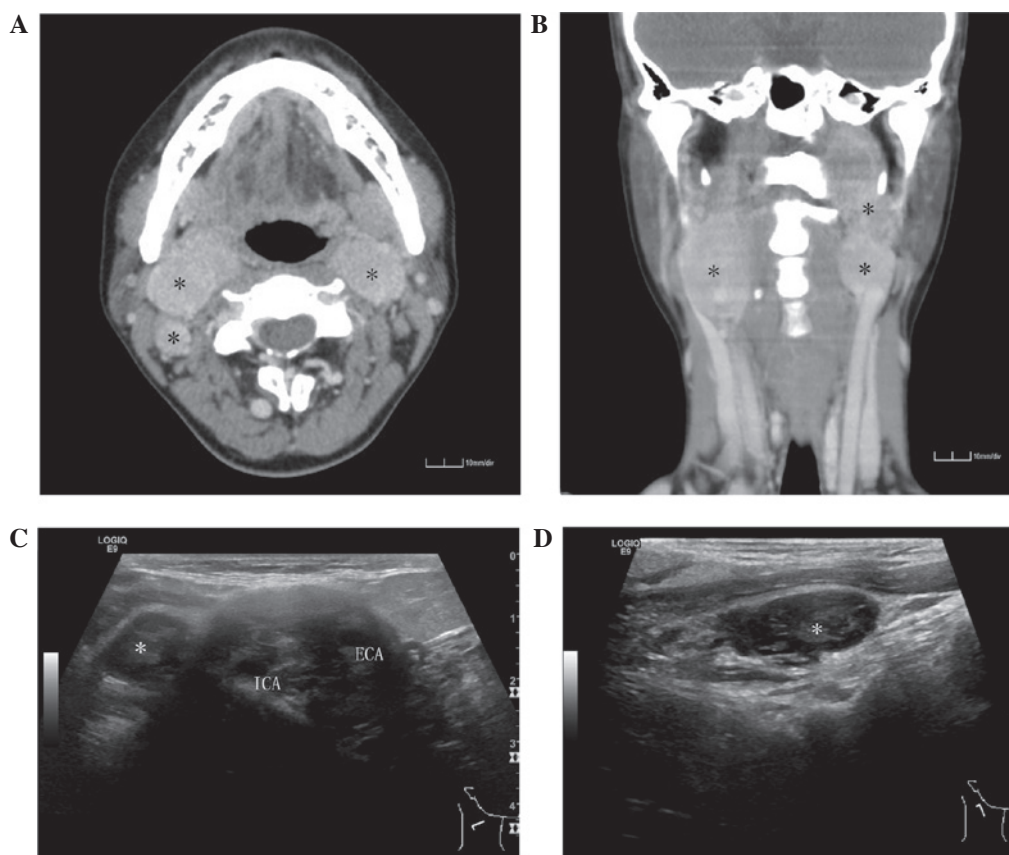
(A) Enhanced-CT and (B) CTA scans revealed the bilateral masses with enhancement (asterisks). (C) Transverse B-mode ultrasounds revealed an inhomogeneous hypoechoic, well-defined mass in the right neck. (D) An enlarged lymph node was also identified in the right side of the neck (asterisk). CTA, computed tomography angiography.
